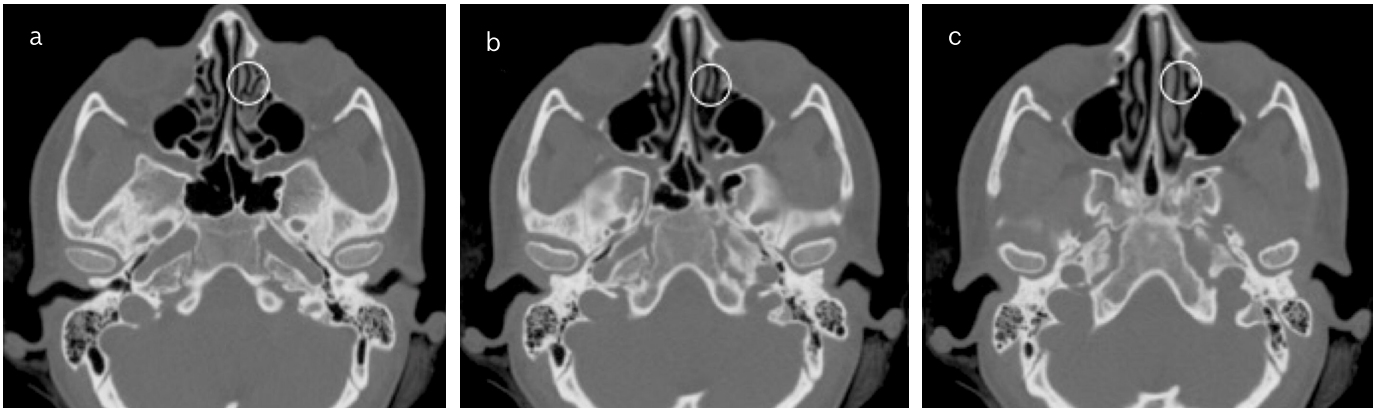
a-c. Computed tomography axial scans of the uppermost portion (a), intermediate, (b), and most caudal part (c) of uncinete process
